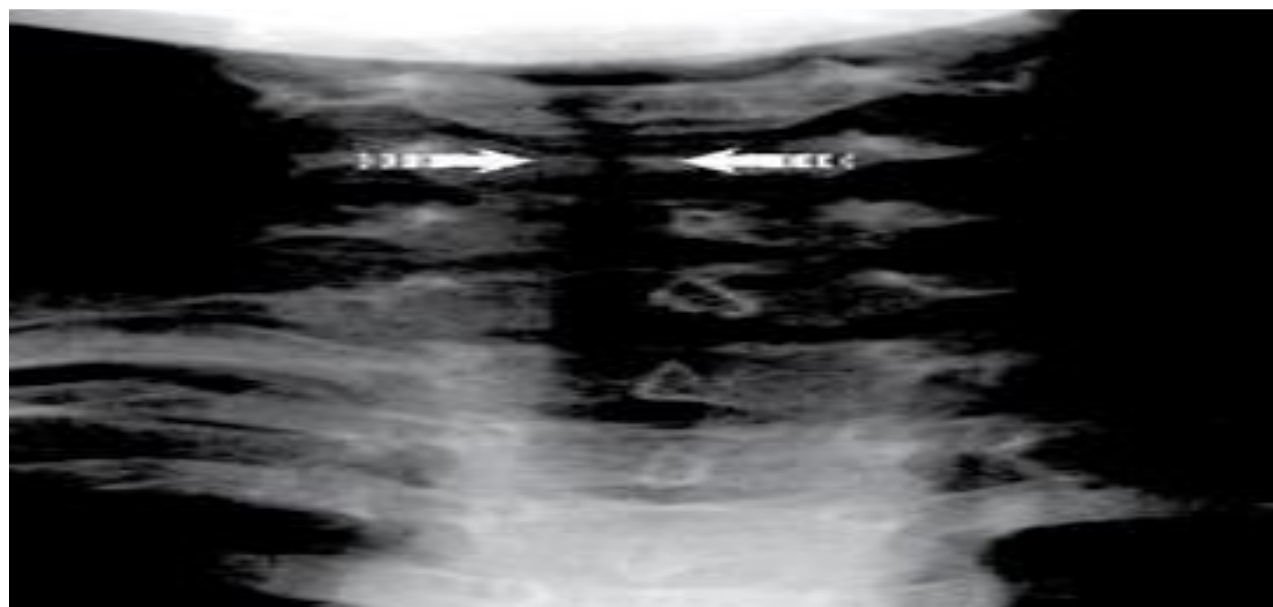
X-ray chest display narrowing of air pillar:
